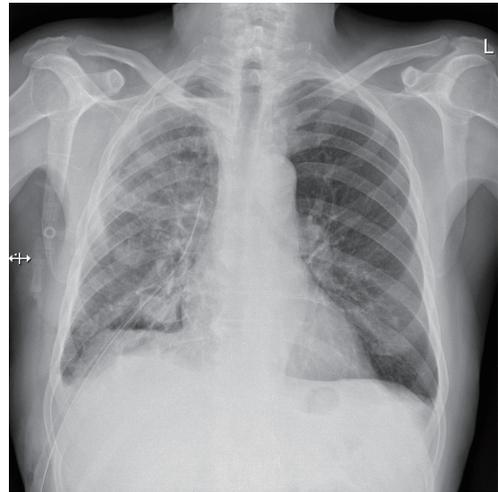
Chest X-ray, posterior-anterior view after the surgical removal of the intermediate lobe of the right lung. Drain in the right pleural cavity. The postoperative chest radiograph revealed no pneumothorax.
